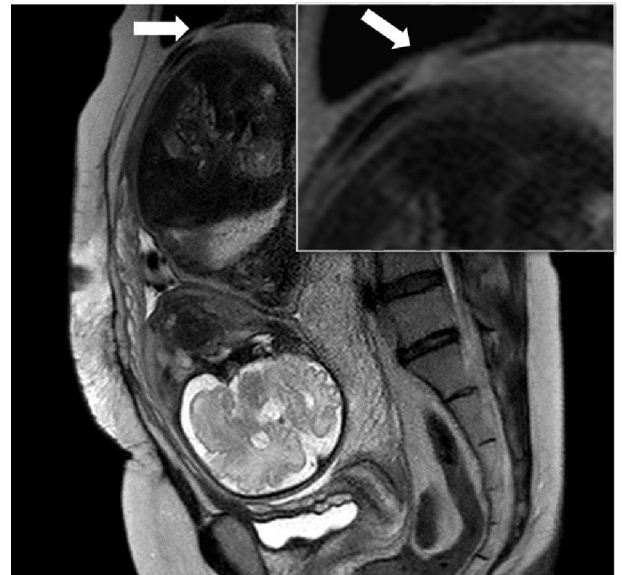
Magnetic resonance imaging (T2-weighted imaging) showed the rupture (arrow).
